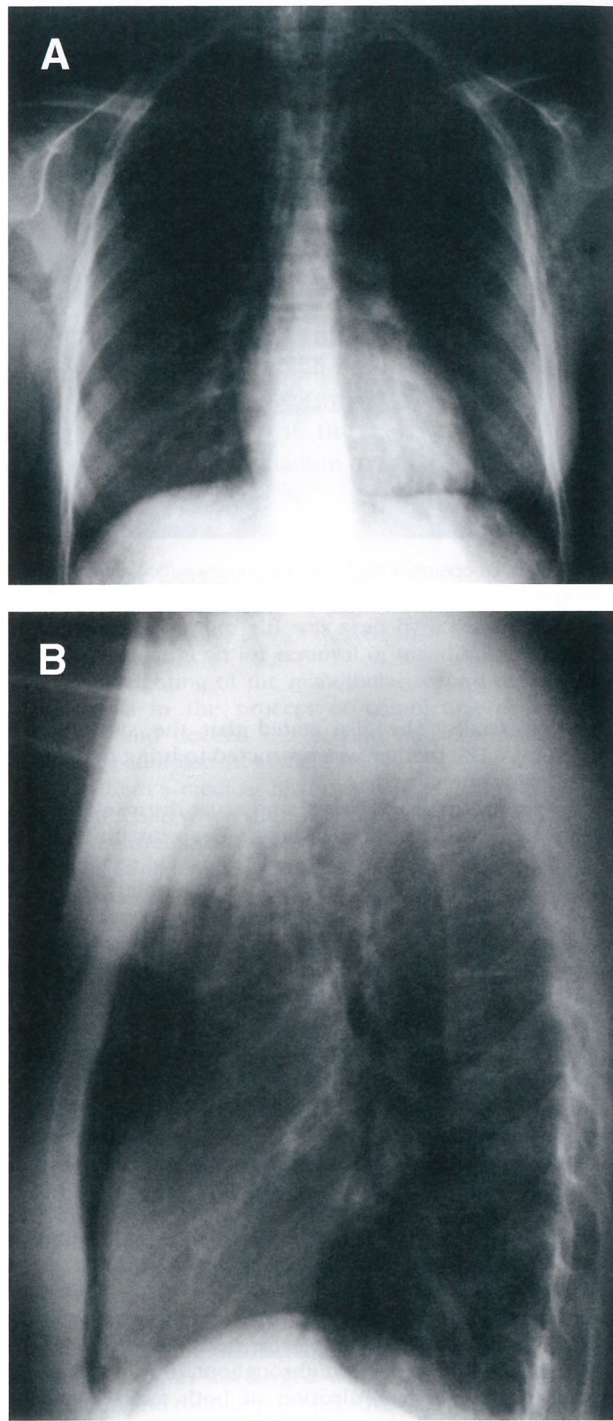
A, PA and B, lateral chest radiographs showing bilateral axillary and anterior chest wall emphysema.
